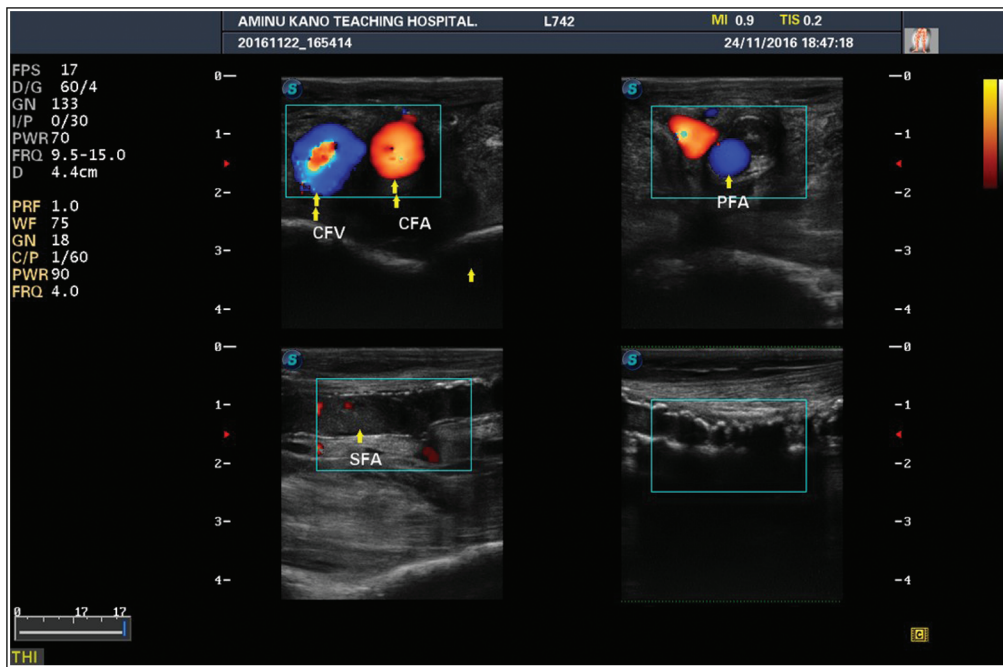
A high-resolution color and power Doppler sonogram of the lower limb of an elderly diabetic with Wagner's grade-3 right ischaemic ulcer. It shows absent blood flow and extensive irregular wall calcifications on the superficial femoral artery (SFA). However, there is good color flow within the common femoral artery (CFA), profunda femoral artery (PFA) and common femoral vein (CFV)
